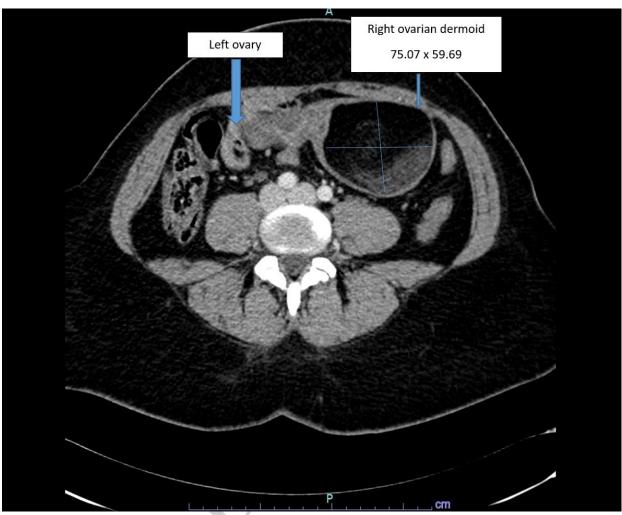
Preoperative CT-abdomen, showing Bilateral dermoids
